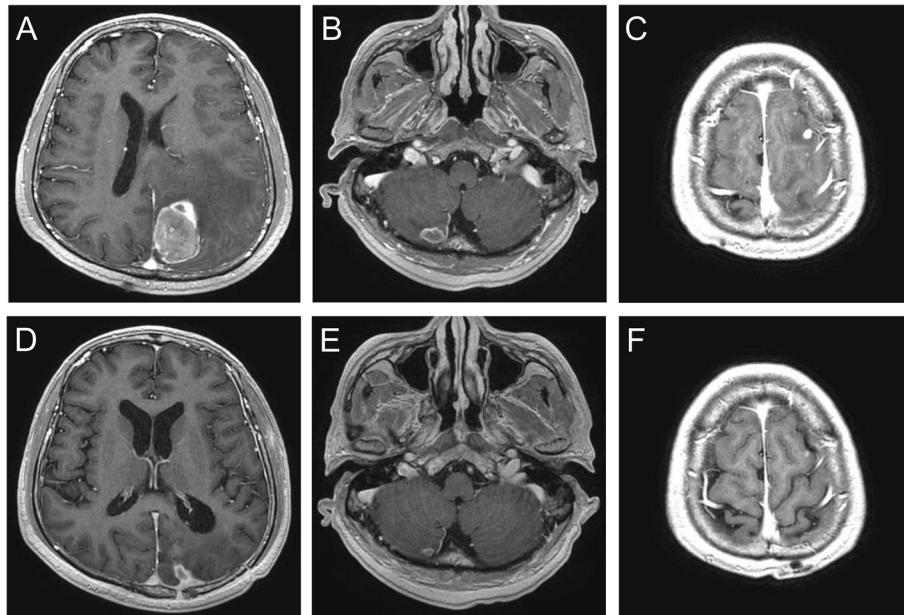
T1-weighted gadolinium-enhanced brain MRI of a 58-year-old man. Oligoprogression lesions were found in the left occipital (A), left frontal lobe (B), and right cerebellum (C). After left occipital tumor excision and adjuvant whole-brain radiotherapy, the patient changed from afatinib to osimertinib. Lesions were controlled well after a 6-month image follow-up (D, E, F)
